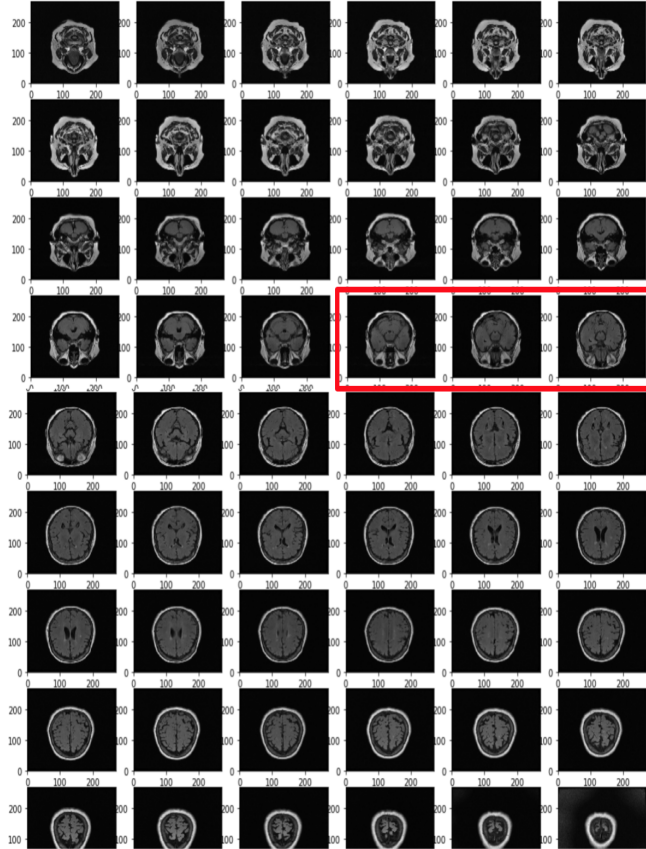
T2 Axial MRI scan of Parkinson's Disease patient, with slices containing substantia nigra highlighted in red. Inset in Figure 3
